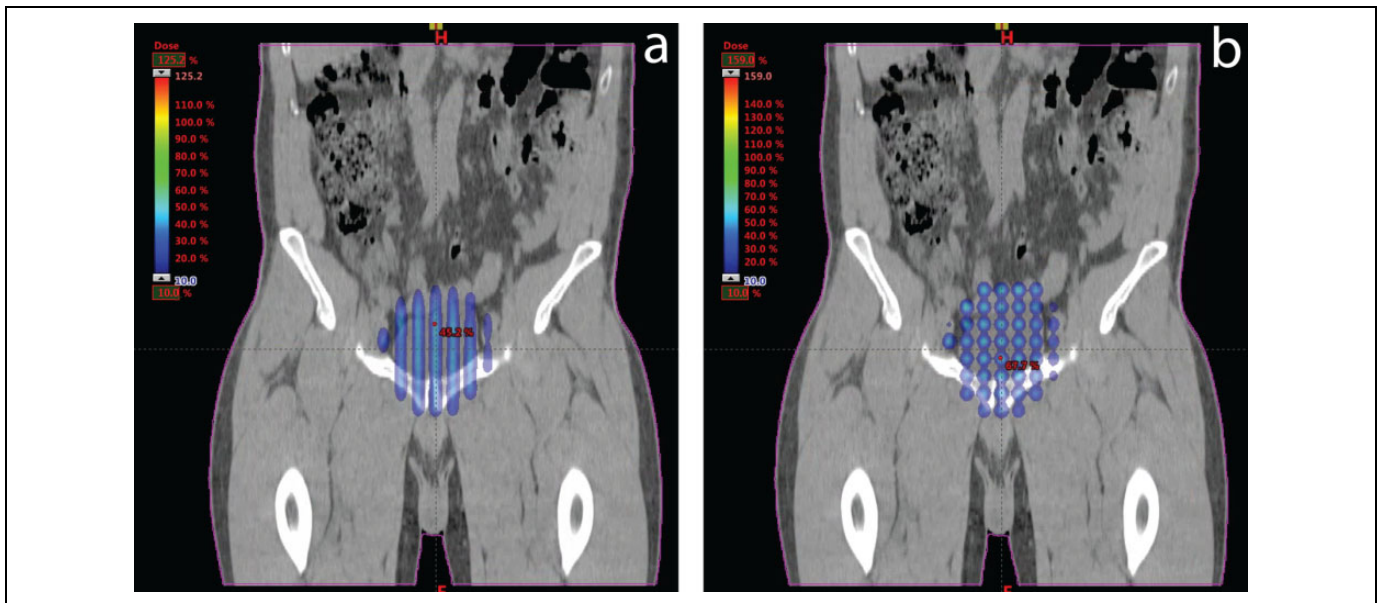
Dose distributions obtained for the 2 types of grid irradiations considered in this work superimposed on coronal computed tomography (CT) sections from the patient with rectal cancer. A, One-dimensional (1-D) grid. B, Two-dimensional (2-D) grid.
